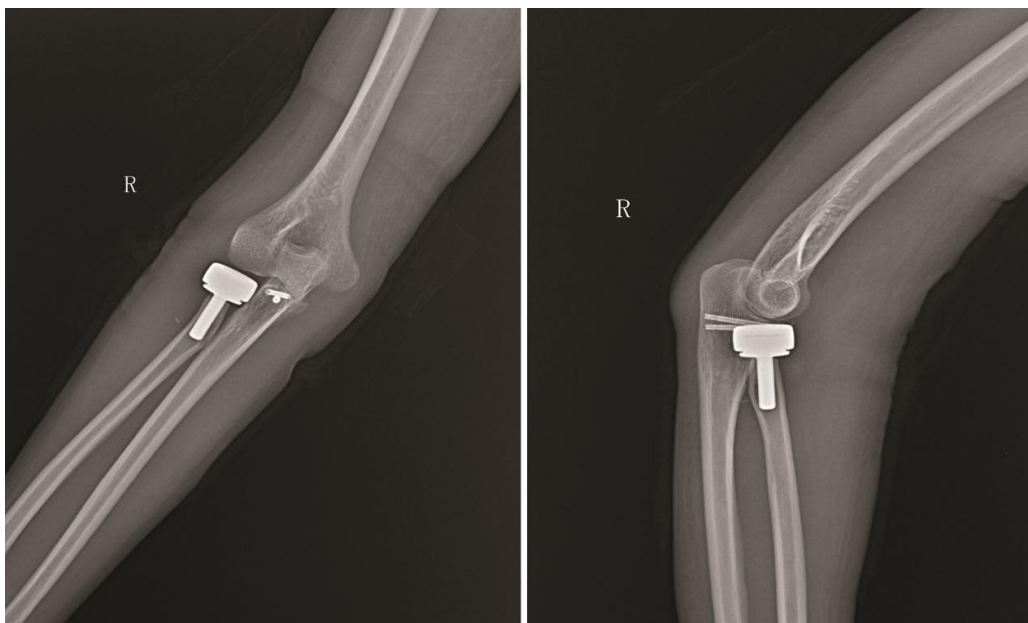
Postoperative X-ray films showed that the internal fixation was in position, and no prosthesis loosening or internal fixation failure was observed
